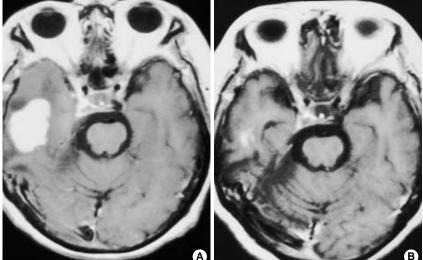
Gd-enhanced T1-weighted MRI at the second neurologic attack shows a lobulated mass in the right temporal area (A), which also almost disappeared, after steroid treatment (B).
